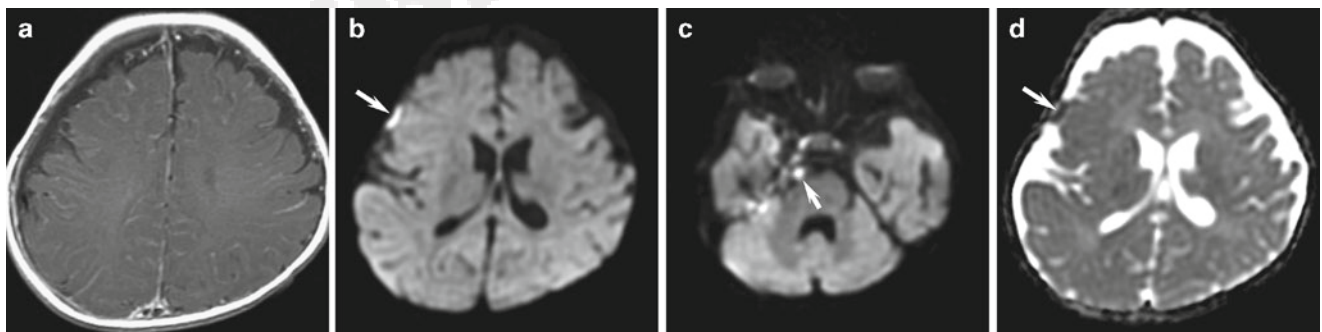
Meningitis and complications. (a) Axial contrast-enhanced T1, (b, c) DWI, and (d) ADC images from a 4-month-old girl with *Staphylococcus aureus* meningitis are shown. On the postcontrast T1 image, there is diffuse meningeal enhancement. DWI and ADC maps
